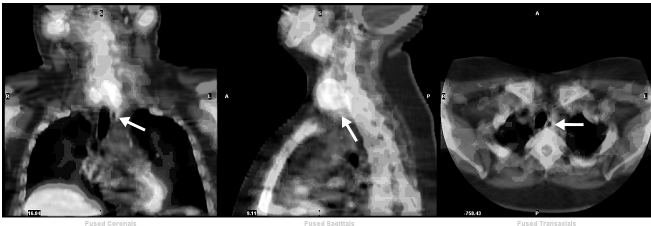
Early phase of cervico-thoracic SPECT/CT performed 10 minutes after injection depicts a left tracheoesophageal groove lesion of faint metabolic activity in coronal, sagittal and axial planes (white arrows)
